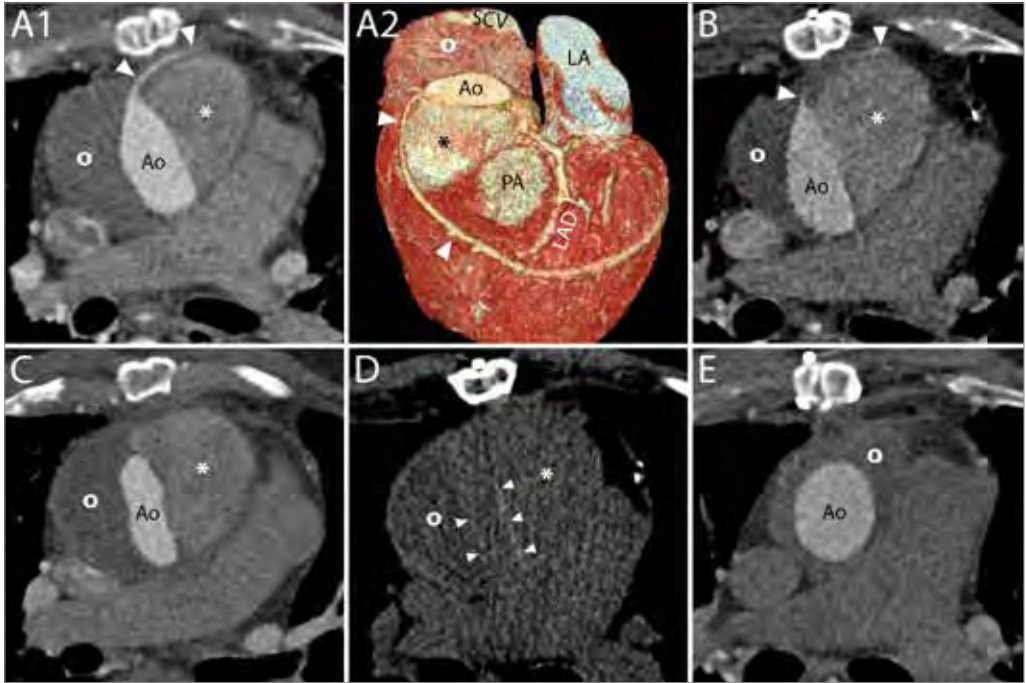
Loss of vein graft following combined Bentall and coronary artery bypass procedure due to progressive compression by two fluid collections. This 68-year-old male patient underwent a combined Bentall and coronary artery bypass procedure for a severely stenosed bicuspid aortic valve and concomitant three-vessel disease. Like most Bentall procedure performed at our institution, the interposition technique was used, implying that the native ascending aorta was excised and replaced by a vascular prosthesis (as opposed to the inclusion technique by which the aneurysm sac is closed around the vascular graft). Routine follow-up CT two months later (A1, A2) showed two fluid collections, one (asterisk) denser than the other (circle), and both moderately compressed the aortic graft and encompassed but did not compress the vein graft (arrowheads). Two follow-up scans were acquired four months (B) and 10 months later (C), which did not show any distinguishable change in size of both fluid collections, but did reveal that the aortic prosthesis—and now also the vein graft (arrowheads)—had become compressed even further (B, C), resulting in occlusion of the vein graft (C). An additional non-enhanced scan (D) did not show any differences in density between the two fluid collections compressing the aortic graft (arrowheads), indicating that the denser fluid collection (asterisk) had to have been partially filled with contrast on all previous contrast-enhanced scans. The patient was thereupon electively reoperated, the leaking right coronary artery button was resutured and the pseudo-aneurysm successfully removed, restoring normal aortic dimensions (E) and leaving only a small hematoma behind (circle). Ao – aorta, SCV – superior caval vein, LA – left atrium, PA – pulmonary artery, LAD – left anterior descending artery.
